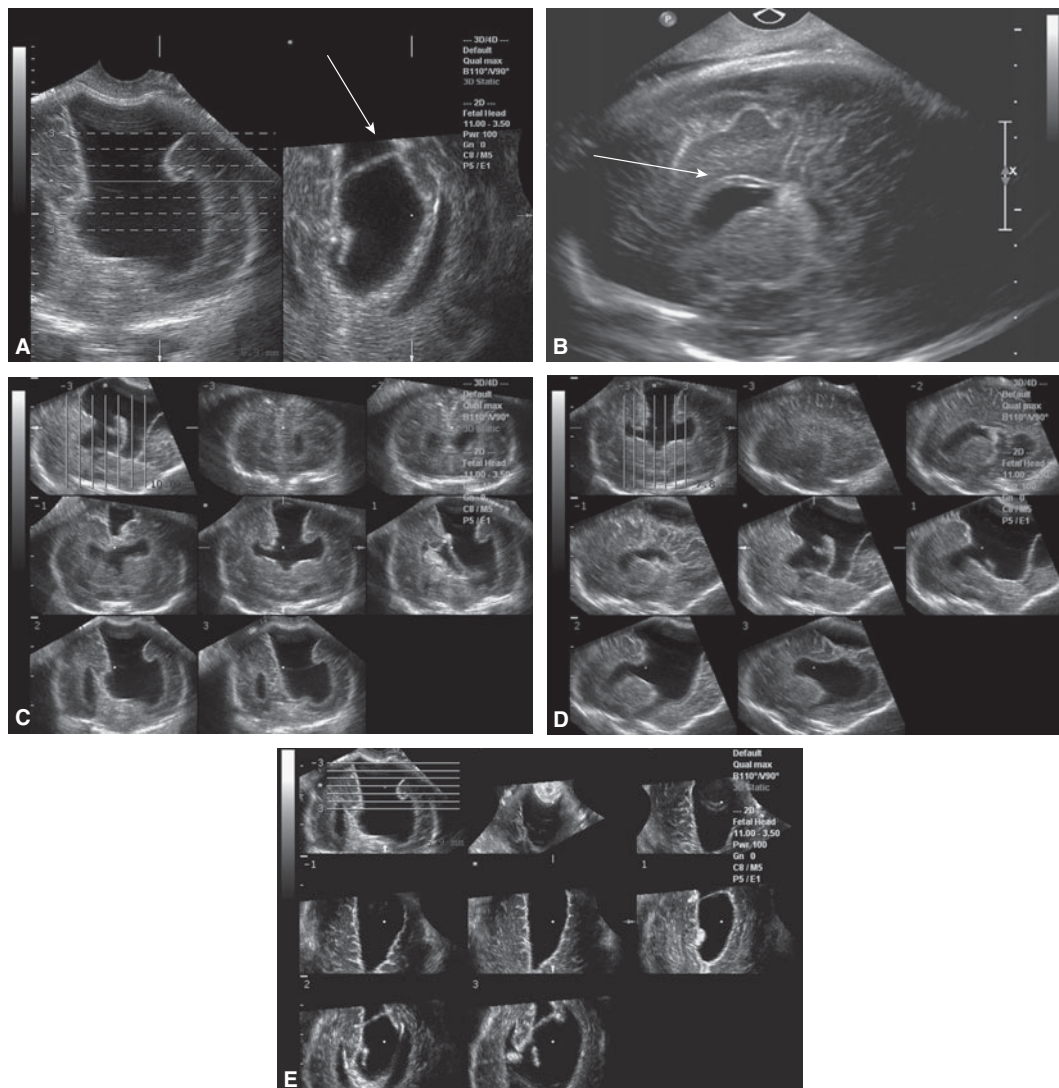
Interhemispheric arachnoid cyst. (A) Two side-by-side coronal views of the cyst. Note the thin cyst wall (*arrow*) that depicts the diagnosis. (B) Although some views raised the suspicion of agenesis of the corpus callosum, this parasagittal image (especially some radially oriented gyri) shows the presence of a laterally displaced but normal-appearing corpus callosum (*arrow*). (C) 3D coronal tomographic sequence of the cyst. (D) 3D sagittal tomographic sequence of the cyst. (E) 3D axial tomographic sequence of the cyst. In addition to the above mentioned possible differential diagnosis of a partial agenesis of the corpus callosum we also considered schizencephaly as an alternative diagnosis. A postnatal MRI confirmed the diagnosis of arachnoid cyst parting the two hemispheres.
